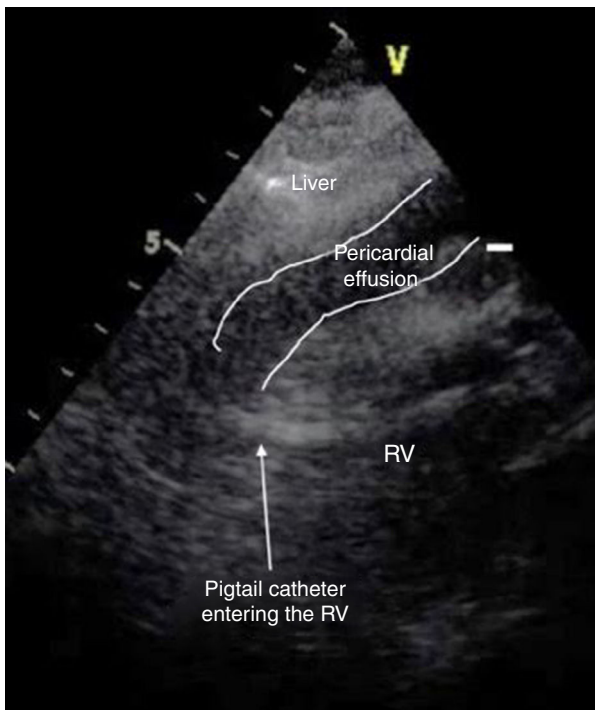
Subxiphoid transthoracic echocardiography showing a large pericardial effusion and the catheter passing through the right ventricular wall. RV: right ventricle.
